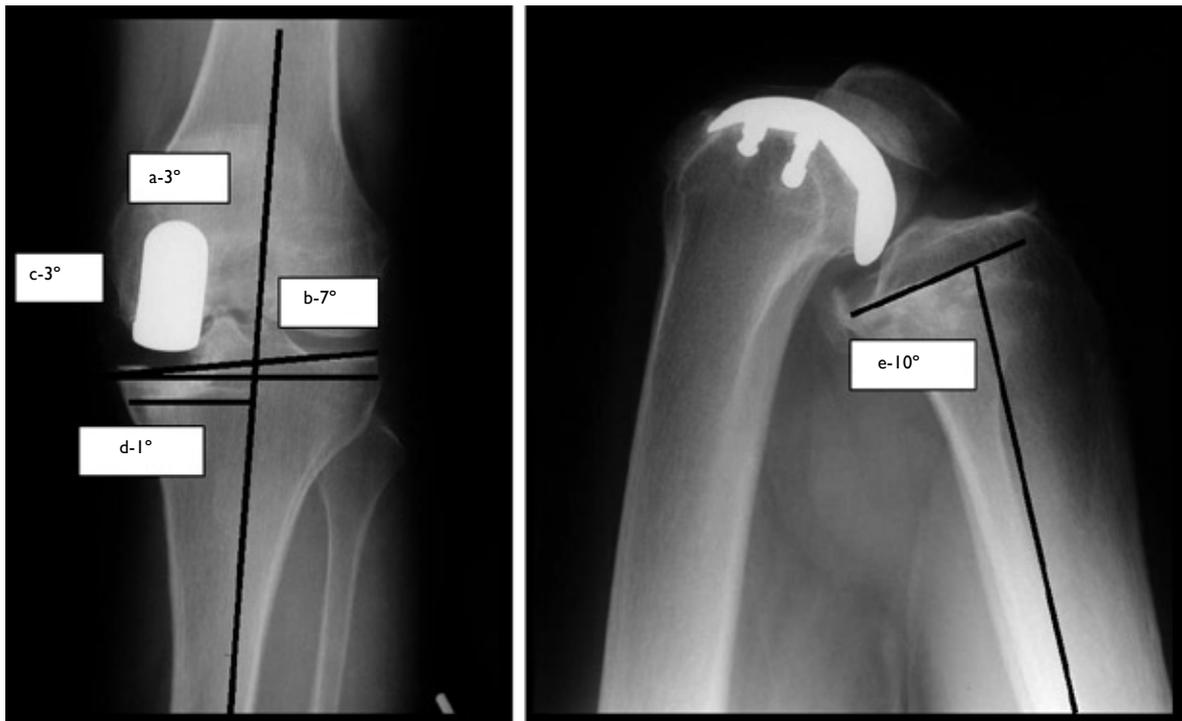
Postoperative radiographs of UKA done in a 56-year-old man shows ideal alignment angles and excellent range of movement. (Patient had preoperative knee score and functional score of 56 and 50, and postoperatives score of 96 and 94, respectively).
